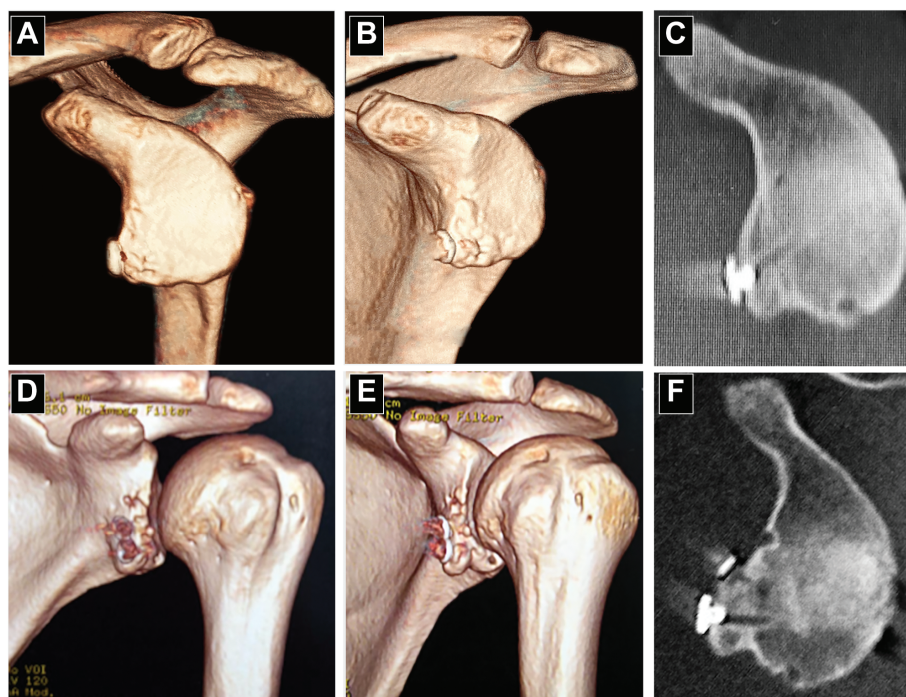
Postoperative 2- and 3-dimensional computed tomography scans performed 6 months after arthroscopic Latarjet demonstrating bone block healing and remodeling: after (A-C) 2-button and (D-F) 4-button fixation. In both cases, there is superior resorption of the coracoid graft with restoration of the pear shape of the glenoid.
